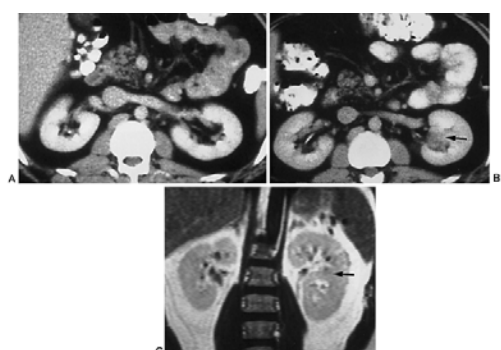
6. Value of the multiplanar capabilities of magnetic resonance imaging (MRI) for renal imaging. A: Baseline computed tomography (CT) scan showed normal kidneys. B: A follow-up CT scan with intravenous contrast showed what appeared to be a mass in the renal pelvis (arrow). This could not be confirmed with ultrasound. C: Coronal MRI of the kidneys with gadolinium enhancement demonstrates a septa of Bertin (arrow), which most likely accounts for findings on this CT scan. No renal mass is identified with MRI.
